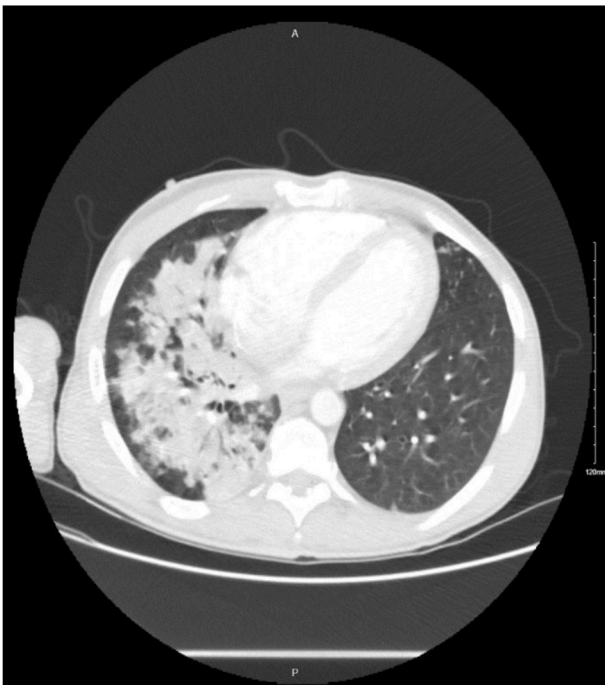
Chest CT scan on first admission showing dense consolidation with air bronchograms.
